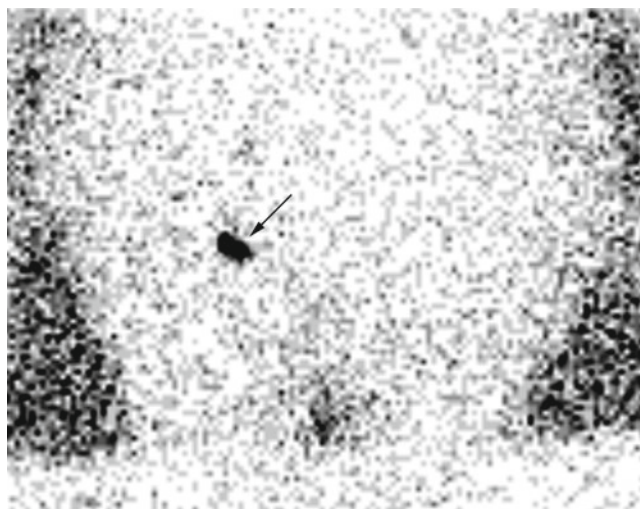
Sentinel lymph-node procedure. Lymphoscintigraphy. Sentinel lymph-node uptake at the right inguinal station (arrow)
